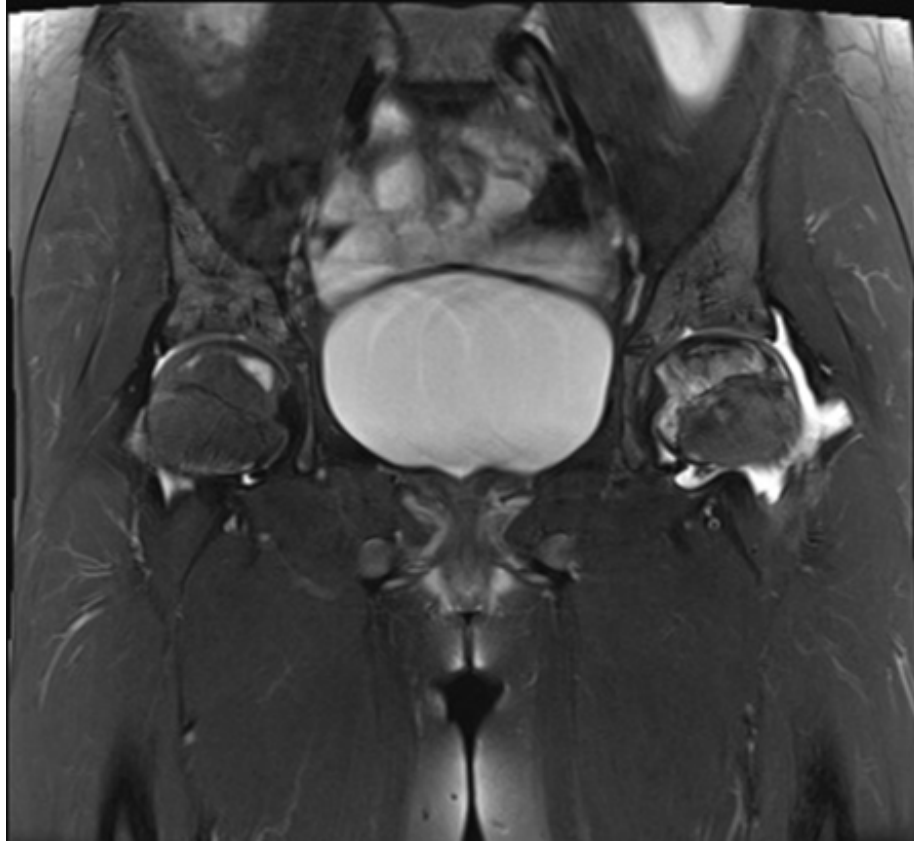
Stage 2 both sides, b: MRI and c: post op
